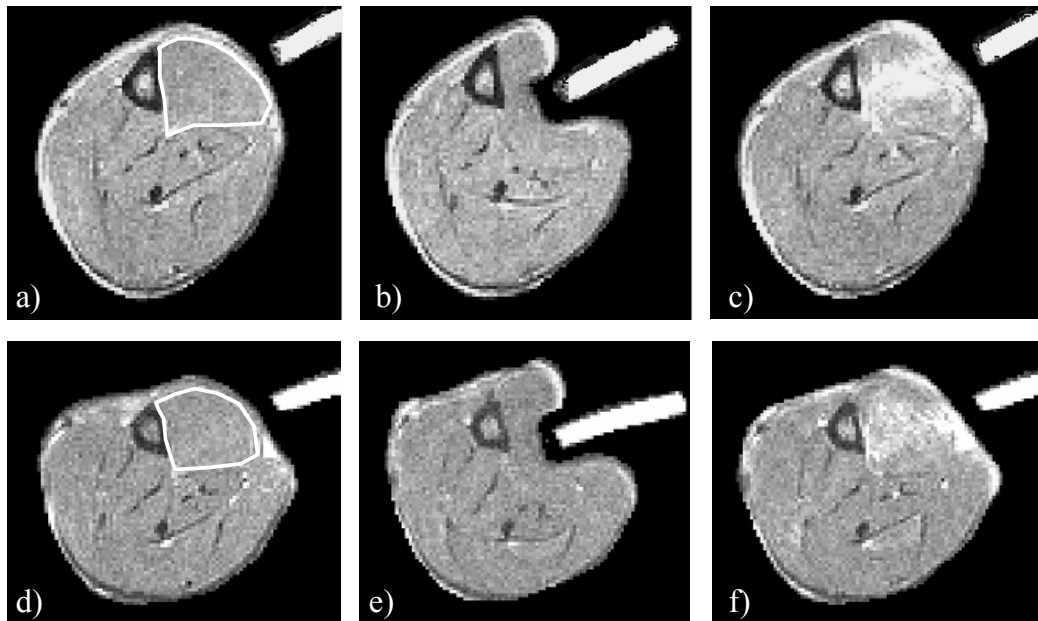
Transversal T2-weighted-sum images underneath the indenter for 2 typical experiments. The first column shows the images taken before loading ($T2_p$), the second column the images taken during loading ($T2_L$) and the last column the images taken immediately after unloading ($T2_U$). TA is indicated by the white line in first images.*
